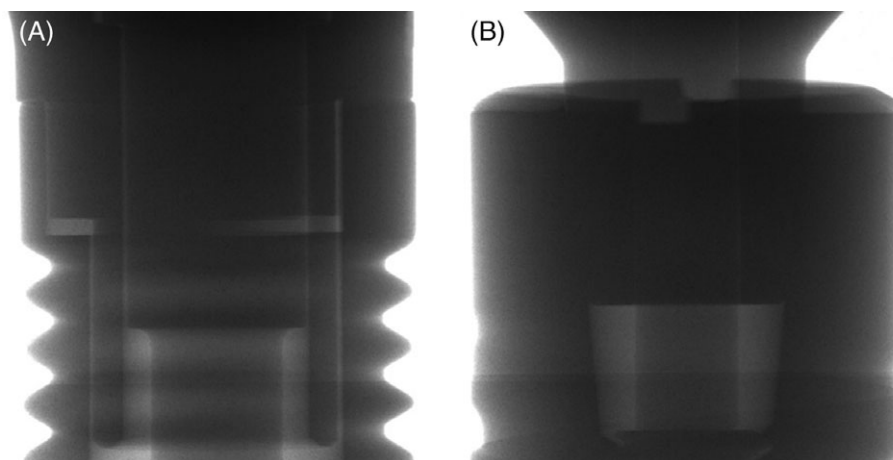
Two-dimensional X-ray images of the implant-abutment joint designs of the 20 implant types investigated in the present study (nonloaded)
